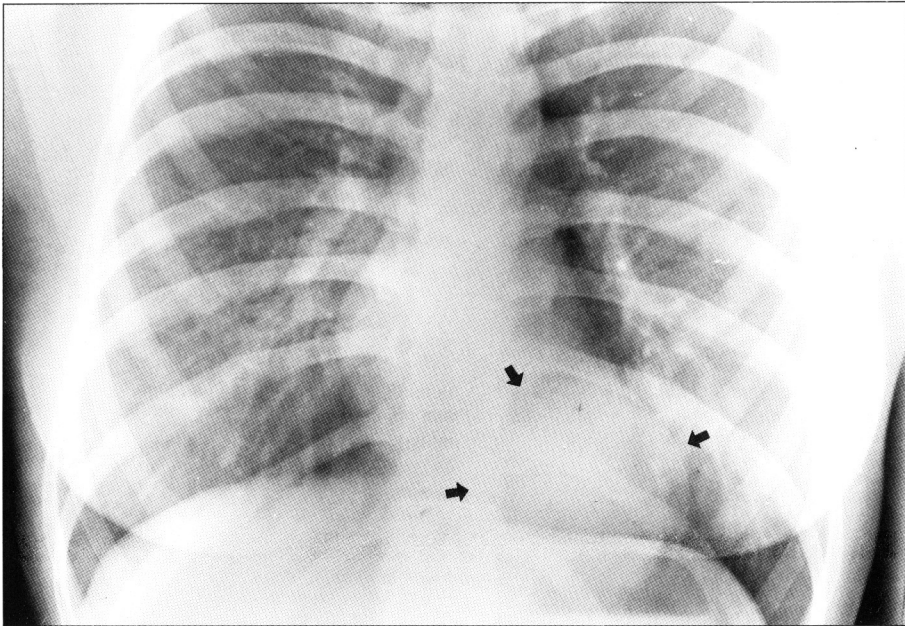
Radiograph obtained 3 weeks prior to admission demonstrates a homogeneous mass density in the left lower lobe(arrows).
